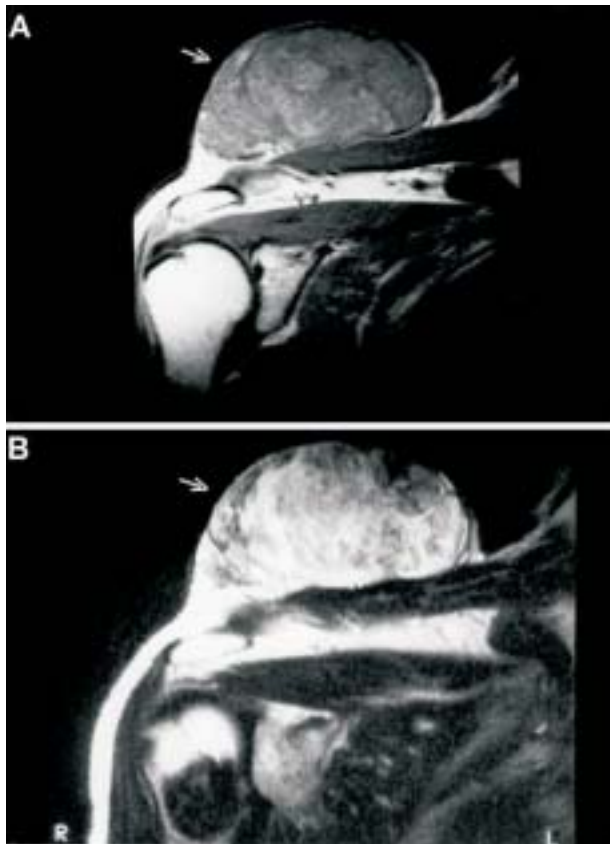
Sarcoma of the right shoulder in a 79-year-old male. (A) Coronal T1-weighted (981/22/2) spin-echo image shows complex inhomogeneity (arrow). (B) Coronal T2-weighted (5500/130/6) spin-echo image also shows complex inhomogeneity (arrow).
